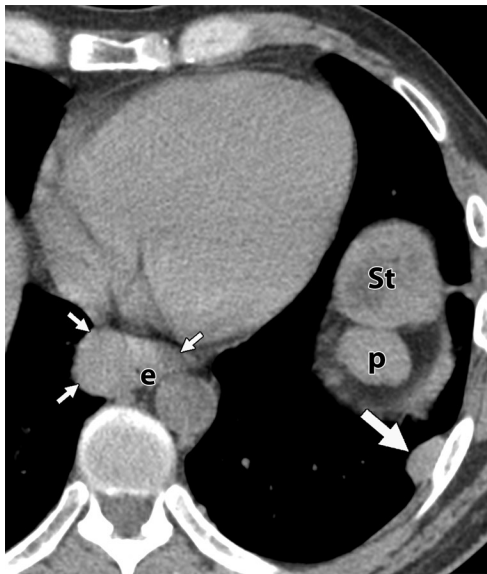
Thoracic splenosis in a patient with a history of remote severe splenic trauma. Axial cropped (a) and ^{99m}Tc–sulfur colloid single photon emission (b) CT images show thoracic splenosis (large arrow), manifesting as a soft-tissue–attenuation mass in the EPS, with radioactive tracer uptake. Another mediastinal implant (small arrows) has similar uptake. The left hemidiaphragm is elevated, and the native spleen is absent owing to splenectomy. Intrathoracic sulfur colloid uptake is always an abnormal finding and indicates the presence of ectopic reticuloendothelial tissue, consistent with thoracic splenosis in this case. *e* = esophagus, *H* = heart, *L* = liver, *p* = pancreas tail, *St* = stomach. (Images courtesy of Stefano Rinaldi, MD, Clínica Alemana, Santiago, Chile.)
